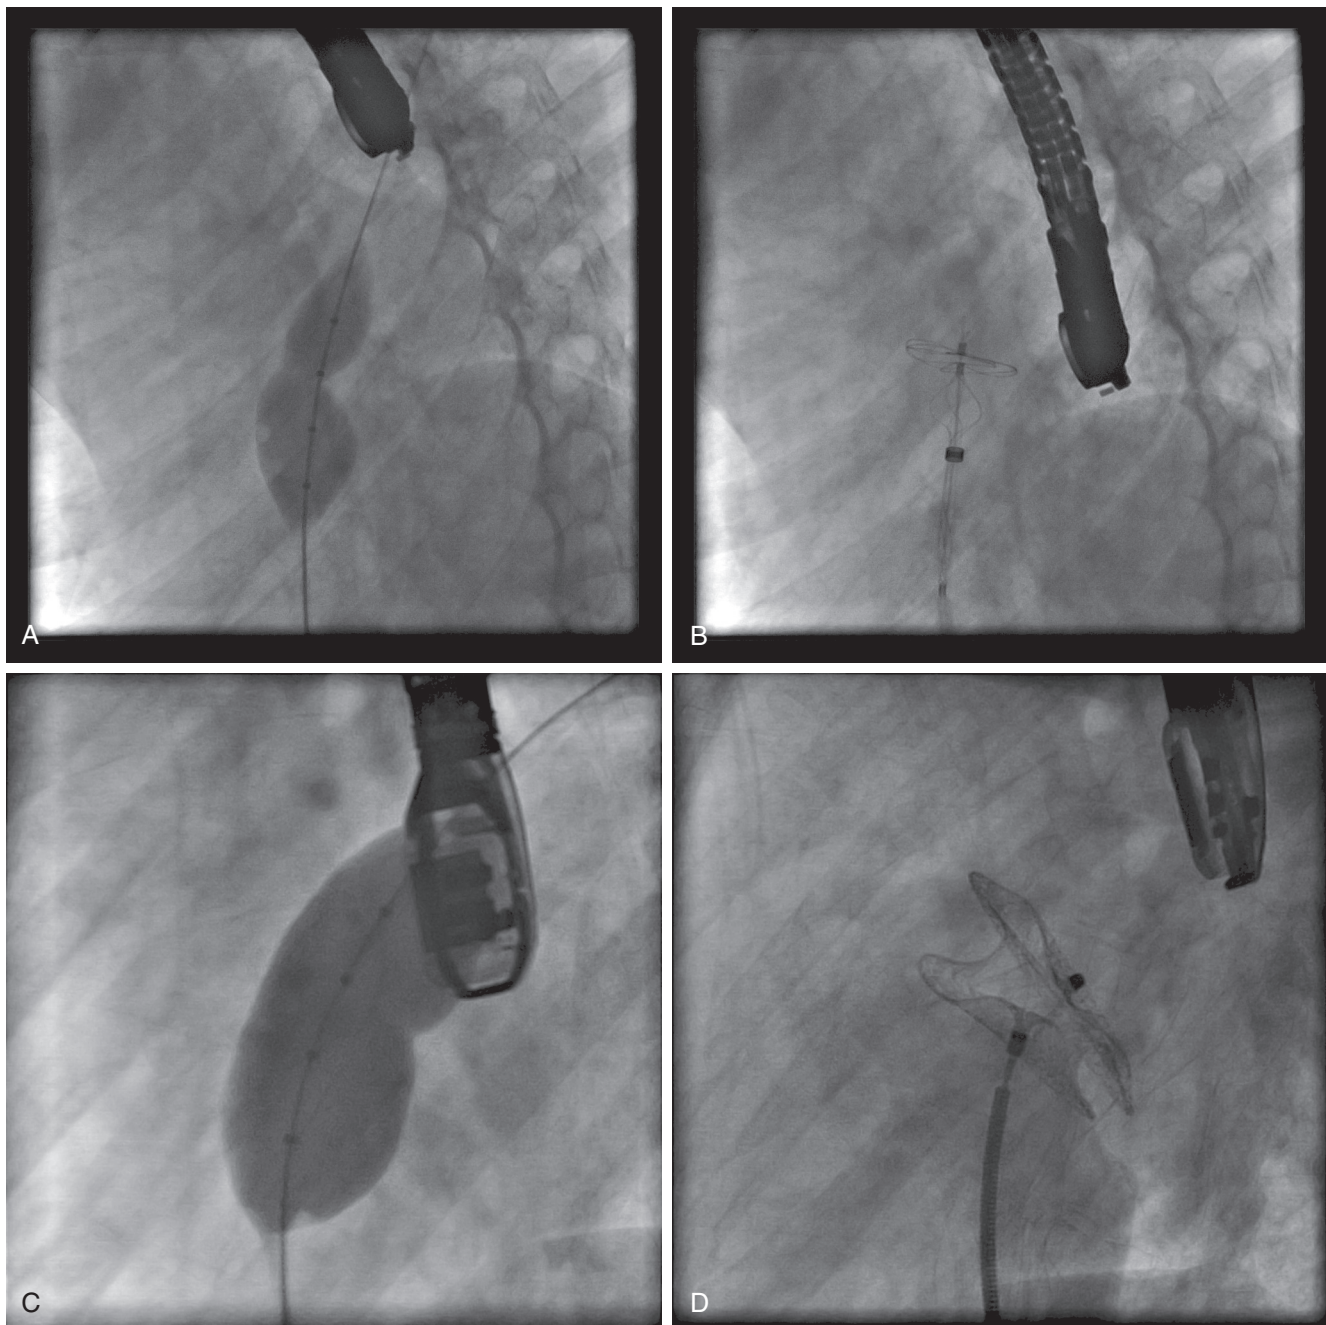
■ Lateral projection images during transcatheter atrial septal defect closure with fluoroscopic and transesophageal echocardiographic imaging. A, Balloon sizing of a small defect. B, Imaging during partial deployment of the right atrial disc after complete formation of the left atrial disc, using a Helex device. C, Balloon sizing of a larger defect with minimal waist apparent on anterior aspect of balloon. D, Following left and right atrial disc deployment of an Amplatzer septal occluder, right atrial angiography aids in confirming appropriate position, particularly inferiorly.
